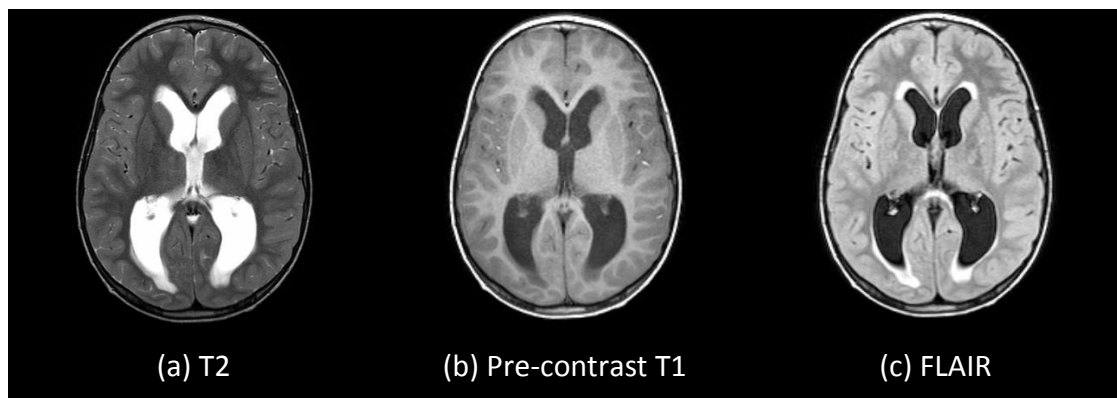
Complementary image contrast of brain tissue acquired based on T2, pre-contrast T1 and FLAIR (case MB718).
